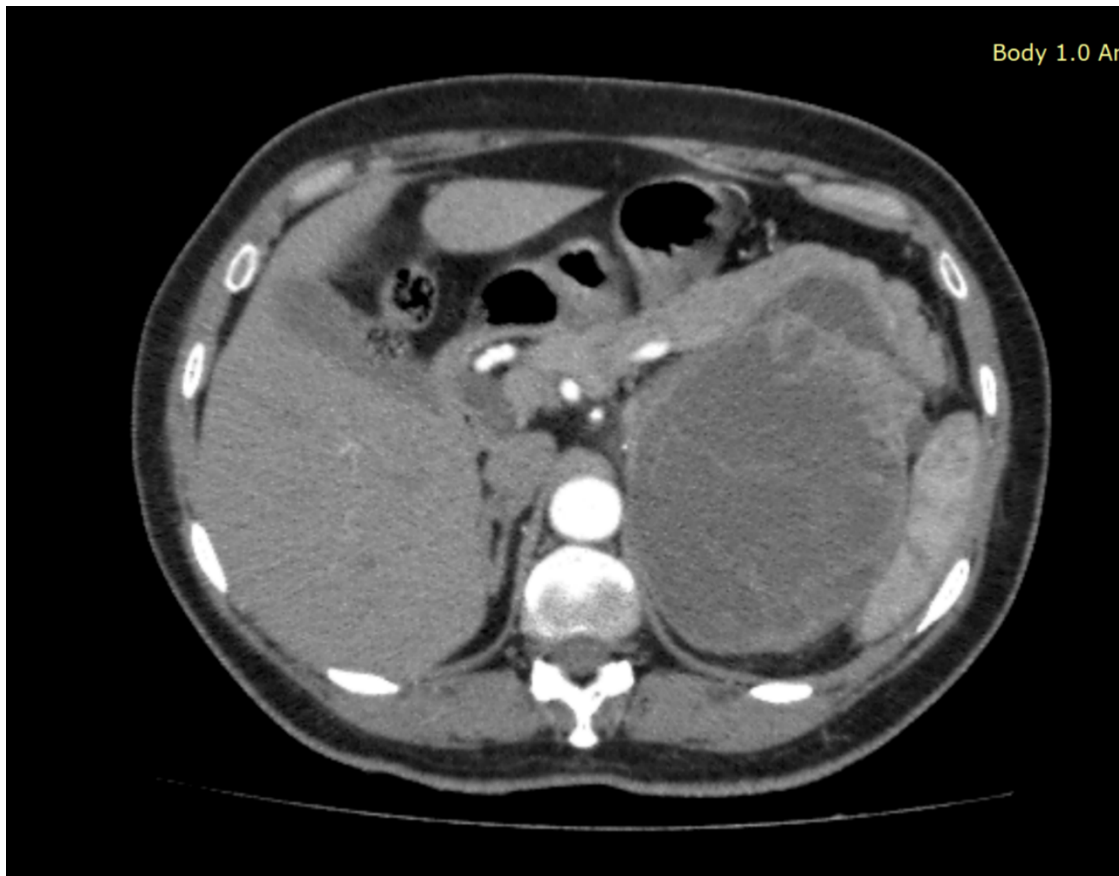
CT scan showing left adrenal mass
